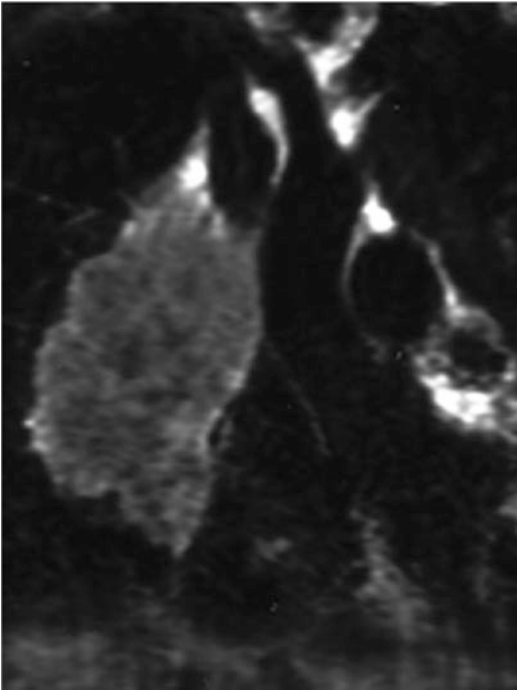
Seminoma. T2-weighted coronal MR image shows a lobulated mass lesion in the anterior mediastinum with homogeneous intermediate signal intensity
